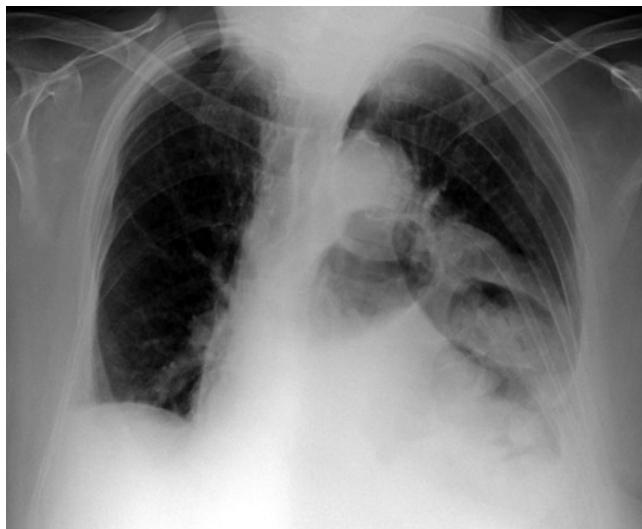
Chest radiograph demonstrating a large left-sided type 4 paraesophageal hernia.
